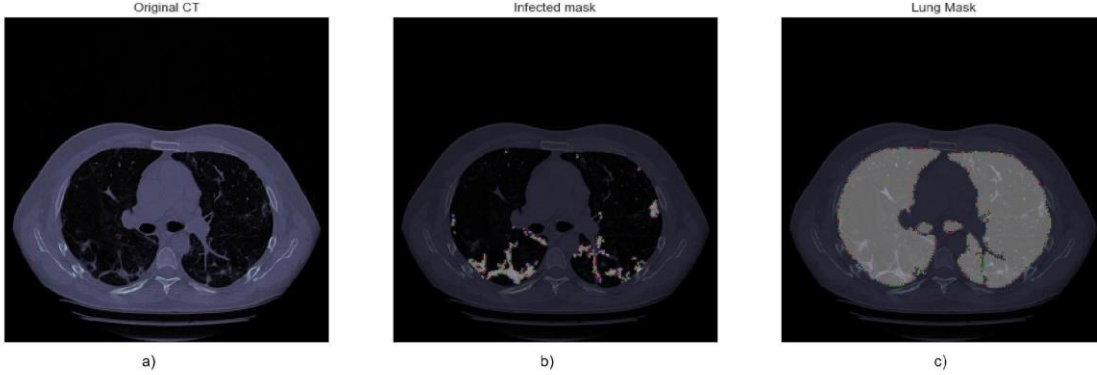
CCTs Pre-processing Technique. (a) A previously selected CT slice with COVID-19 disease. (b) The infection masks. (c) The segmented lung masks. Images (b) and (c) were obtained from the original CT slice (a).
